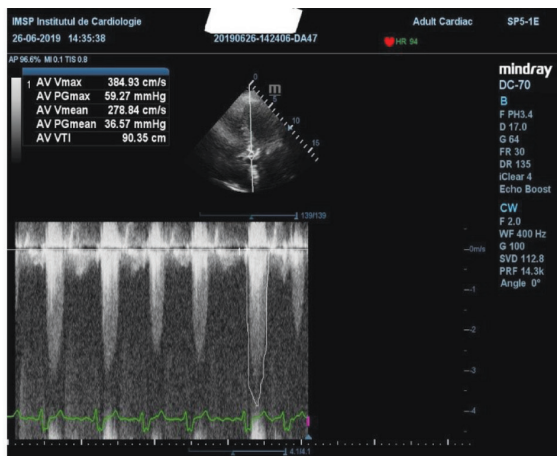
Echocardiography, patient No 2
